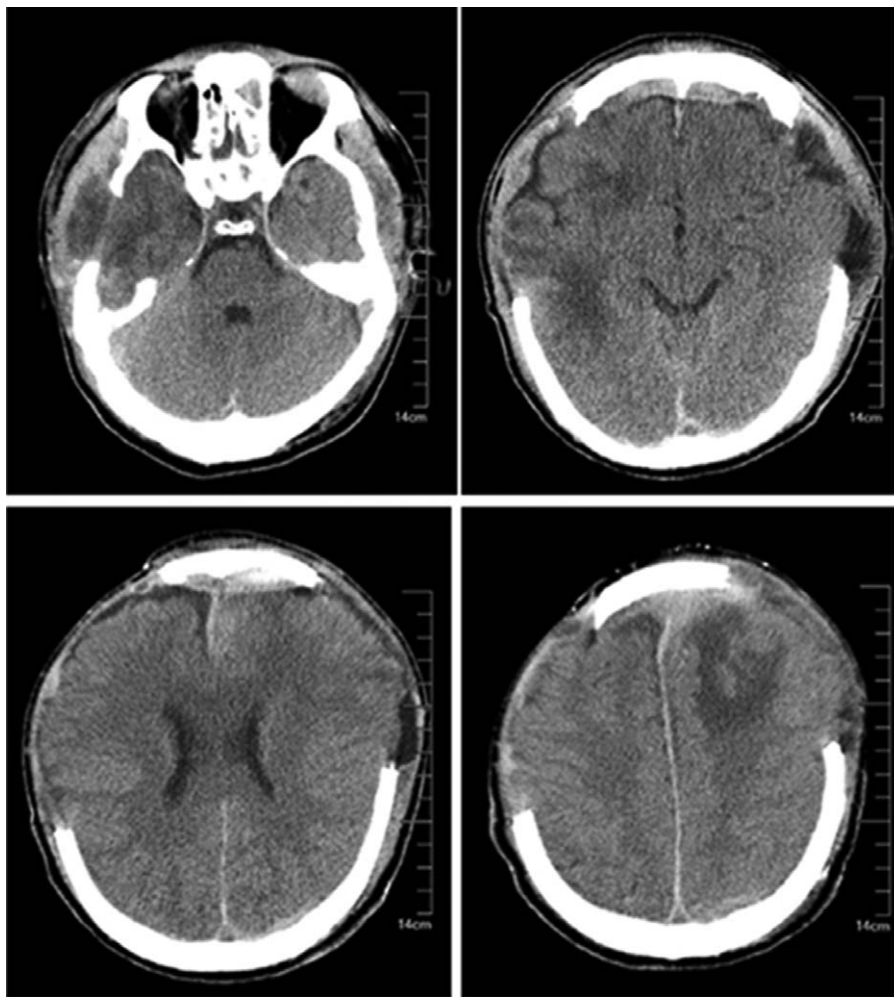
Computed tomography imaging after admission.
